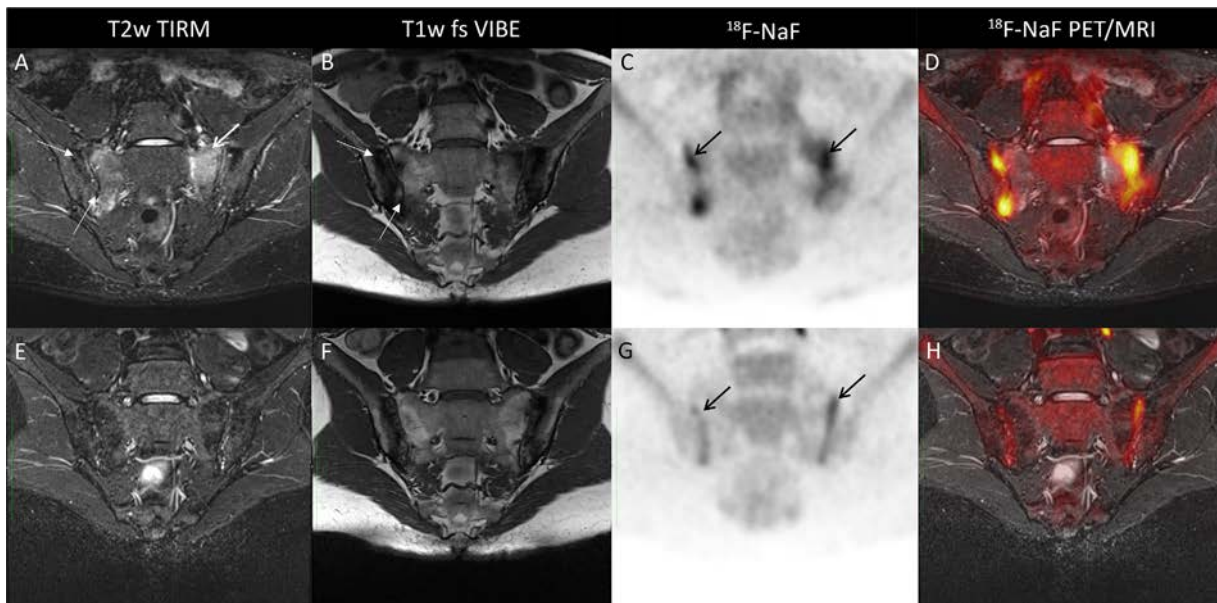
Findings of sacroiliac joint imaging at baseline (A–D) and follow-up (E–H) for a 34-year-old patient with clinically active radiographic axial spondyloarthritis. Shown are areas of sclerosis and erosions (thin white arrows) and extensive surrounding bone marrow edema and fatty degeneration (thick white arrow) on scans obtained by a T2-weighted turbo inversion recovery magnitude (T2w TIRM) sequence (A) and T1-weighted volumetric interpolated breath-hold examination with fat suppression (T1w fs VIBE) (B), as well as evidence of osteoblastic activity based on increased signal on fluorine 18–labeled NaF (^{18}F -NaF) PET/MRI (C and D; black arrows). Follow-up imaging after 4 months of tumor necrosis factor inhibitor treatment showed significant decrease in osteoblastic activity (black arrows). See Figure 1 for other definitions.
